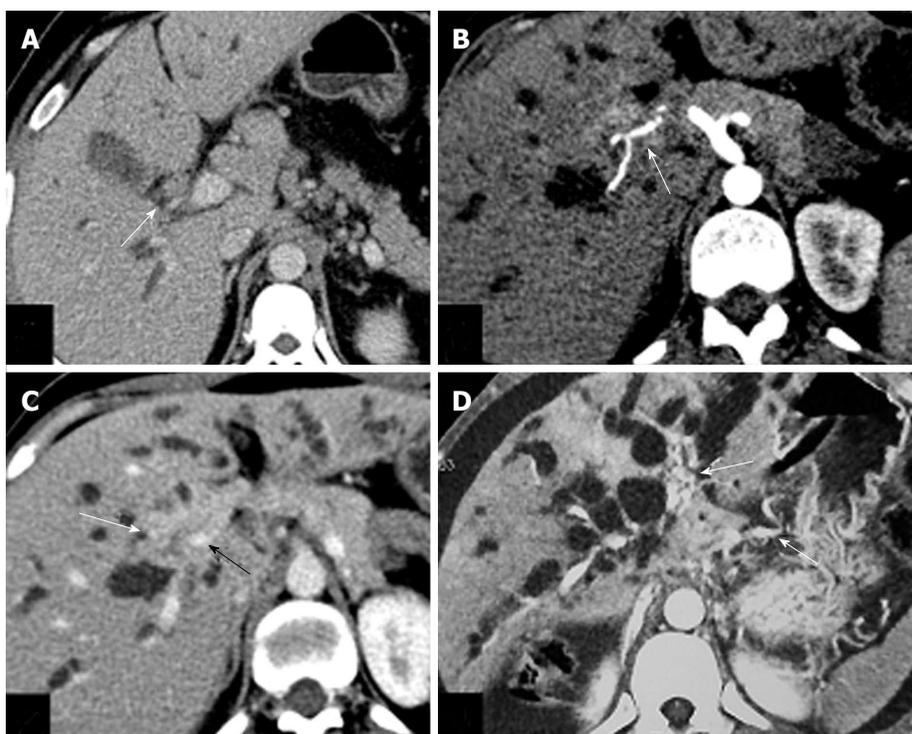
Axial computed tomography scan images showing vascular invasion. A: Small hilar mass (white arrow) abutting right hepatic artery posteriorly; B: Hilar mass (white arrow) encasing right hepatic artery causing irregularity in outline; C: Ill-defined hilar mass (white arrow) encasing portal vein and causing its narrowing (black arrow); D: Multiple collaterals (white arrows) seen in periportal and perigastric location due to portal vein obstruction.
